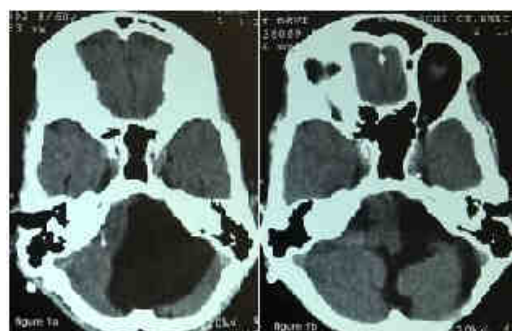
Pre-operative CT brain of 60 year old female having left cerebellopontine angle arachnoid cyst presented with headache and gait disturbances.
